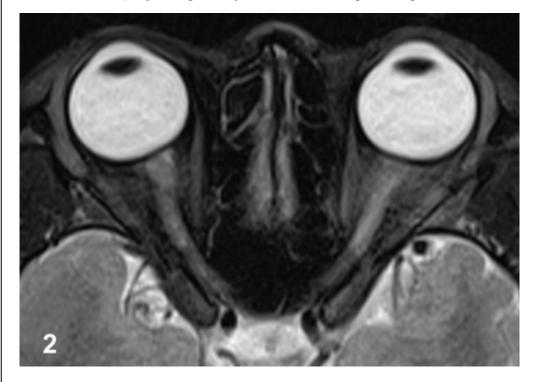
MRI of orbits showed contrast enhancement of bilateral optic nerve, consistent with optic neuritis.
